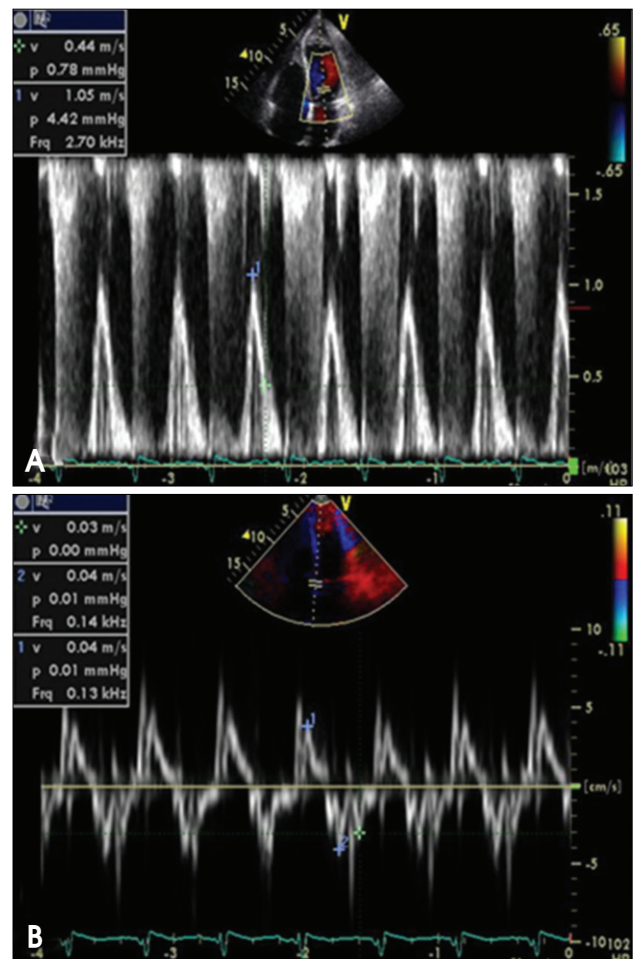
Initial mitral inflow (A) and tissue Doppler image (B) show restrictive left ventricular filling pattern.
